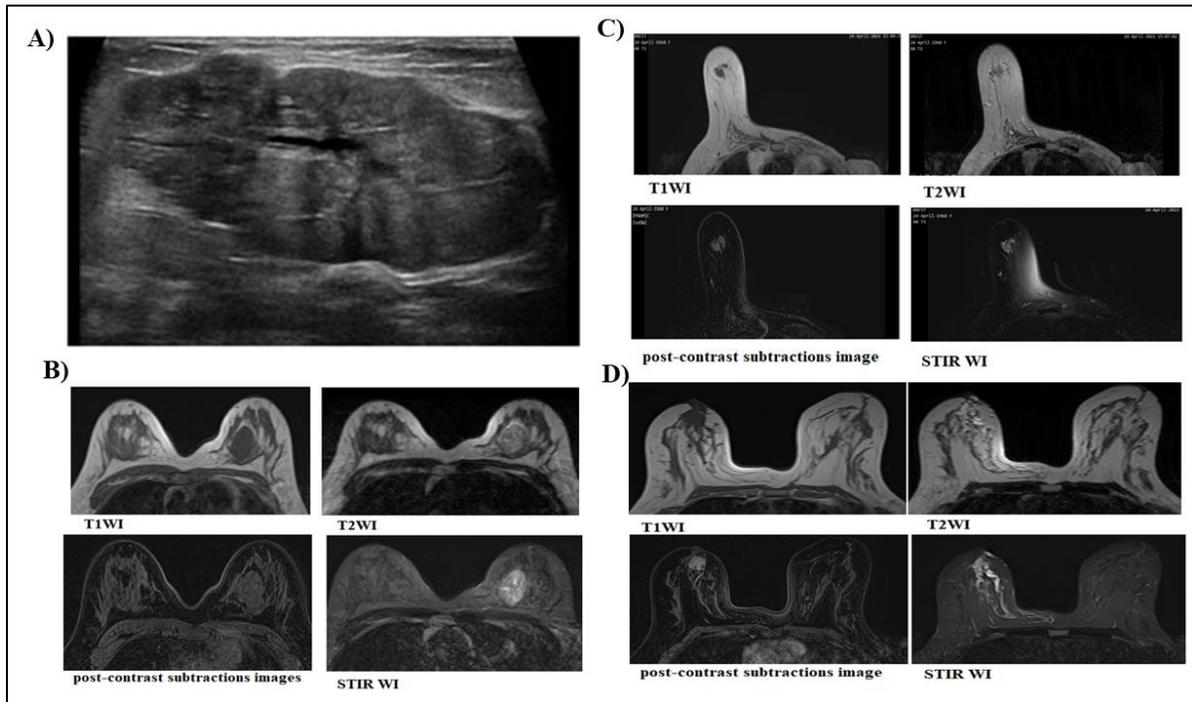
Example of our included patients. A) and B) demonstrates US picture of two palpable masses and MRI images of the lesions of a twenty-three years old female patient presented with a left palpable painless breast mass. C) shows the MRI findings of a fifty-four years old female patient who underwent a modified radical mastectomy of the left breast two years before and received chemo and radiotherapy, then in her annual follow-up revealed two retro areolar right breast masses, the patient has a family history of breast cancer. D) provides the findings of the MRI of a forty-three years old female patient presented with right breast retro-areolar painless palpable mass, patient has a family with no history of breast cancer.
